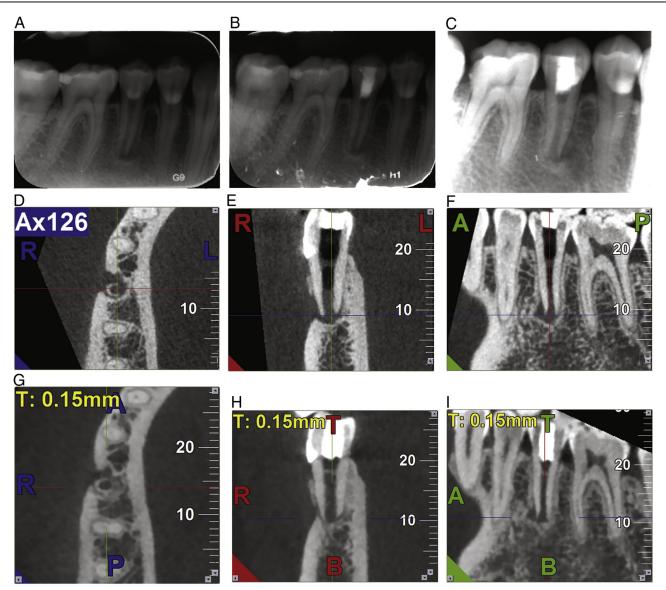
Periapical radiographs and CBCT sections of tooth #29. (*A*) Preoperative periapical radiograph showing extensive periapical radiolucency and open apex. (*B*) Radiograph taken at 8-month recall. The periapical lesion has not changed in size. (*C*) Periapical radiolucency reduced in size after 30 months. (D–F) Preoperative CBCT image. Images from different angles showed the extent of bone defect, especially cortical bone loss on the buccal aspect. (*G*–*I*) Thirty-month follow-up CBCT image revealed bone reconstruction and reduction of radiolucency. Root length and thickness remain unchanged compared with the preoperative CBCT scan. The *yellow* T indicates image thickness; the *red* T indicates top aspect. A, anterior aspect; B, bottom aspect; P, posterior aspect; R, right side.
